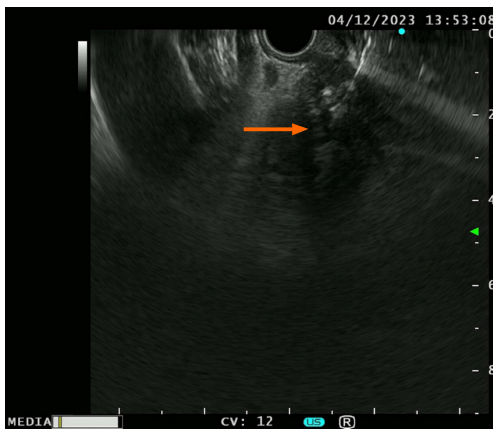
Retrospective analysis of endoscopic ultrasound imaging in the current case. Suspected ductal structure within the fanning area of the target (orange arrow).
